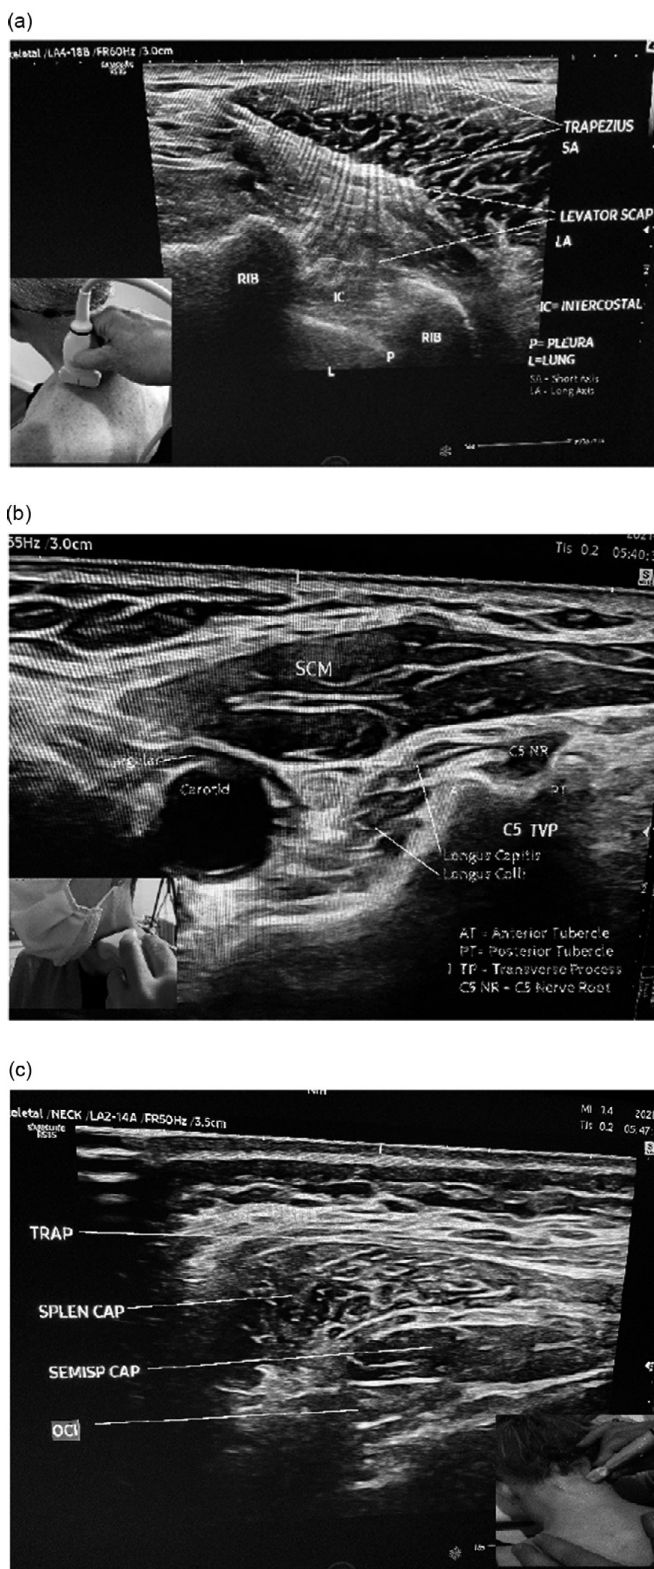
(a) B-mode ultrasound image of levator scapulae (long axis), trapezius (short axis). (b) Short-axis B-mode ultrasound image of longus colli and capitis at C5 level. (c) Short-axis B-mode ultrasound image, posterior neck muscles.
